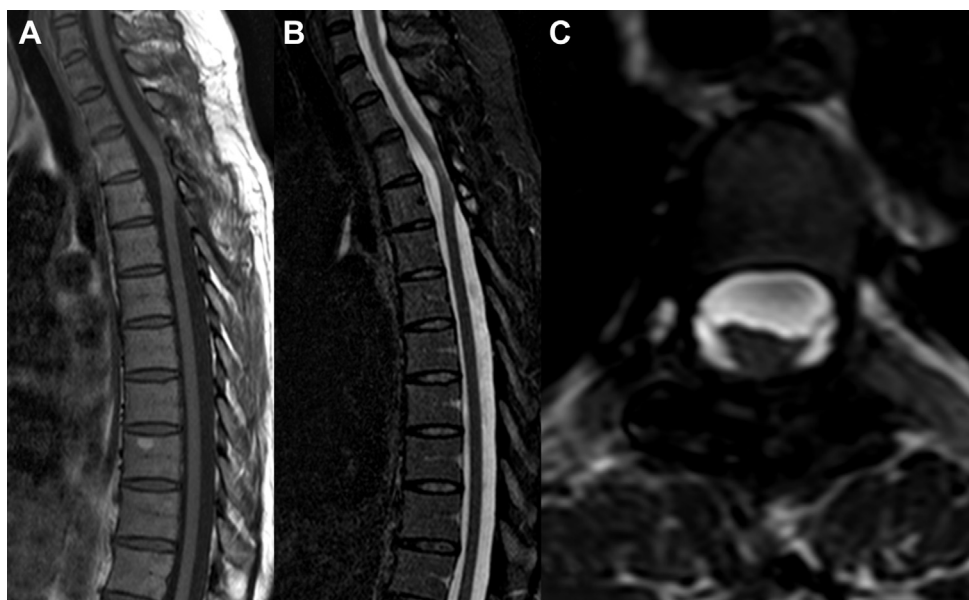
Magnetic resonance imaging obtained at 4-year follow-up. (A and B) Sagittal and (C) axial images
